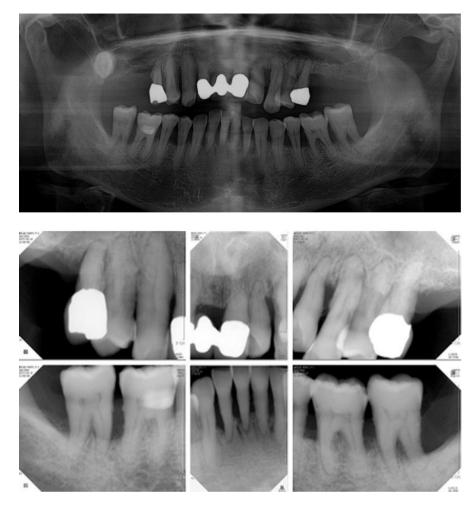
A panoramic radiograph and intraoral radiographs from the patient's first visit revealed generalized chronic advanced periodontitis. The remaining maxillary teeth appeared unsalvageable.
